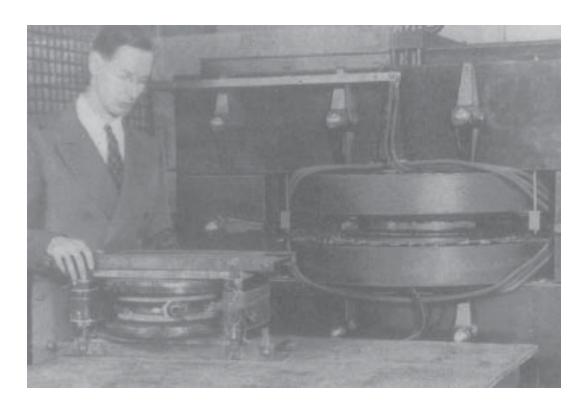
Professor Donald Kerst with two of his betatrons (1940). A betatron is an electron accelerator. These betatrons were compact and able to accelerate electrons to high energies. Electrons that reach sufficiently high energies are able to penetrate deeply into tissue; therefore, accelerated electrons can be used therapeutically. Additionally, the betatron-accelerated electrons were relatively monoenergetic and their energy was easy to control. Source: Laughlin JS. Radiation therapy. *RadioGraphics*. 1989;9(6):1254. Photograph: Courtesy of John S. Laughlin. Medical Physics Department, New York, NY.
